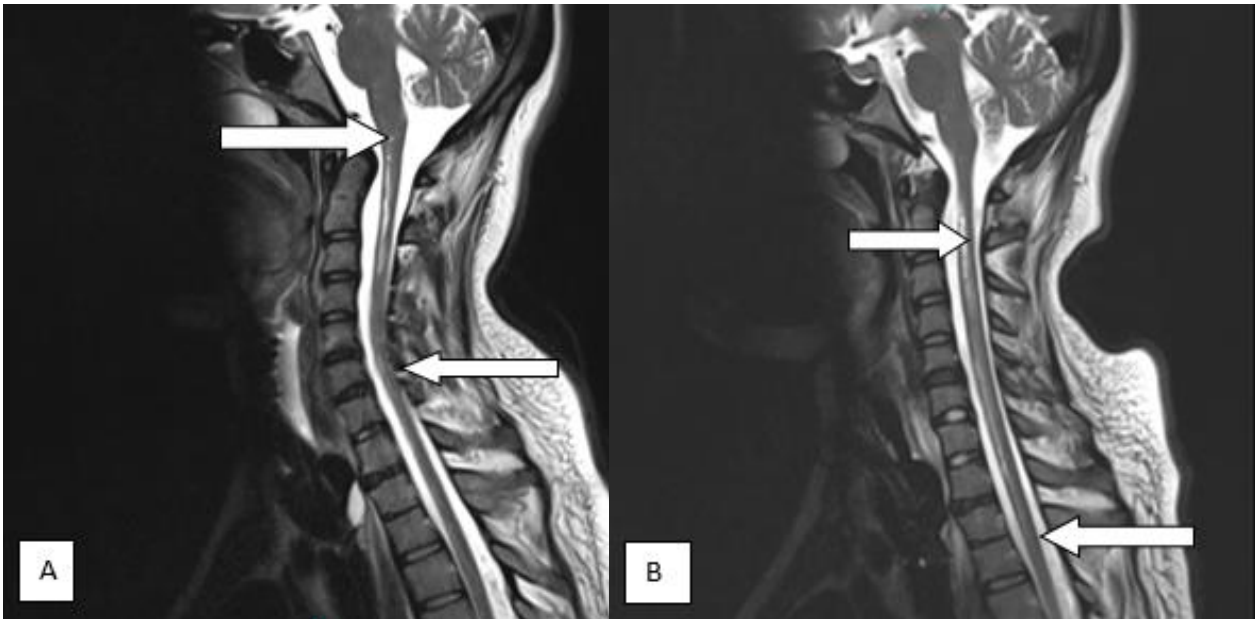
Cranial and cervical MRI: Arrows show increased T2 hyperintense pathological signal consistent with ASA infarction starting from the bulbus level and continuing along the C1-T1 vertebra.
